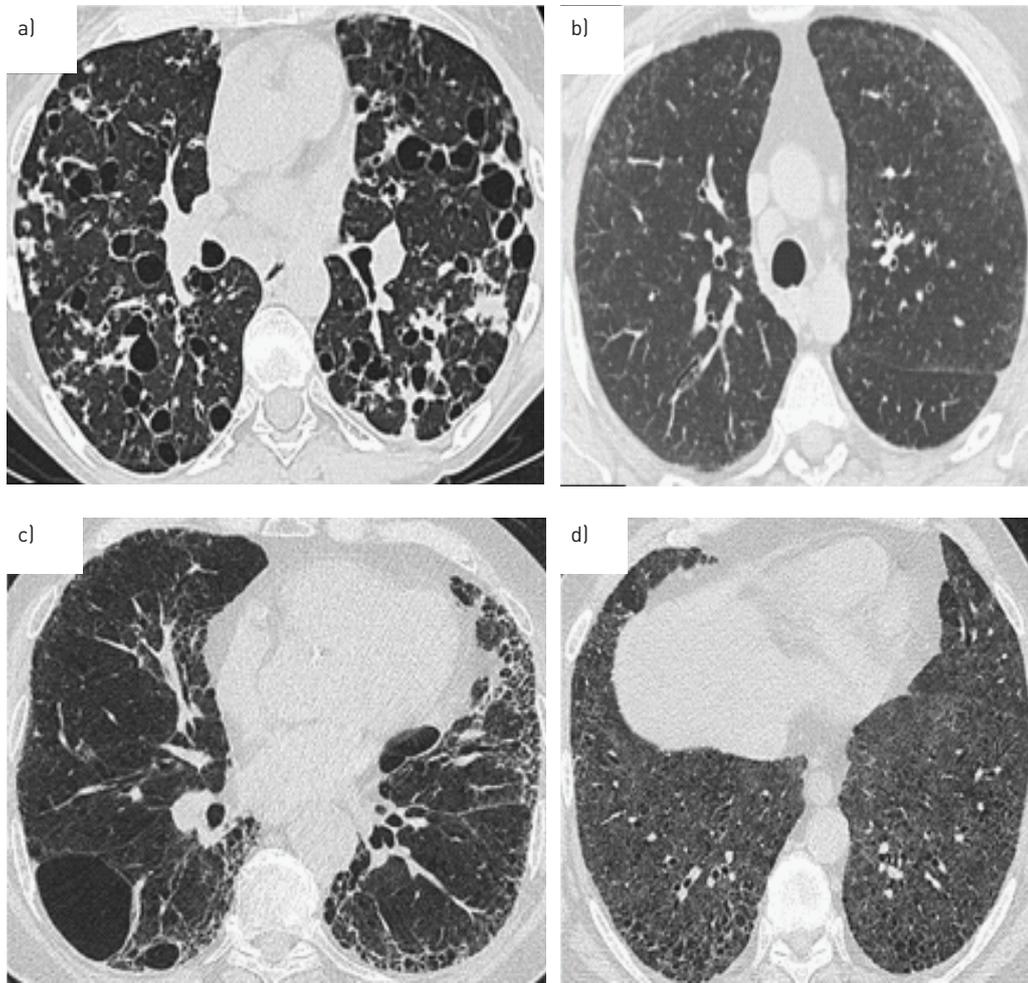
High-resolution computed tomography images of smoking-related interstitial lung diseases (ILDs). a) Pulmonary Langerhans cell histiocytosis, b) respiratory bronchiolitis-associated ILD, c) combined pulmonary fibrosis and emphysema, and d) desquamative interstitial pneumonia.
